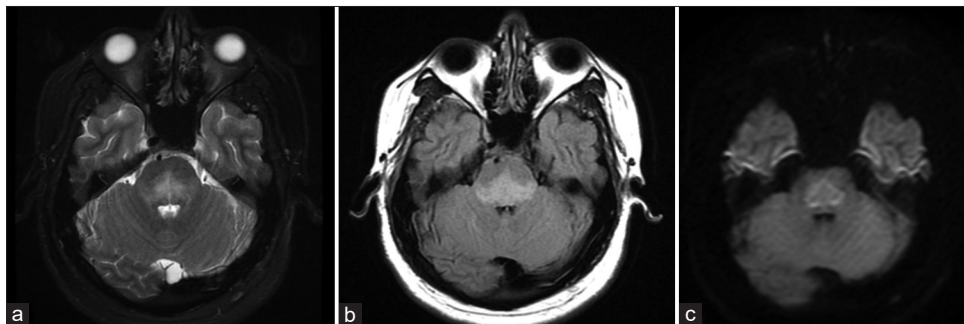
(a) Axial T2-weighted (T2W), (b) fluid-attenuated inversion recovery (FLAIR), (c) diffusion images of the brain showing classical trident/omega sign as hyperintensity on T2W and FLAIR and restriction on diffusion images
